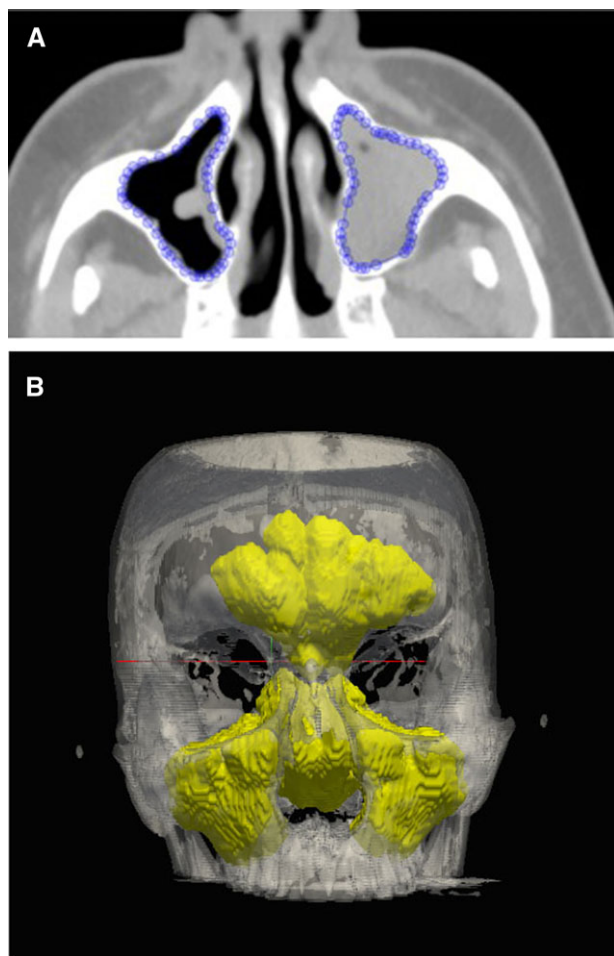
(A) Manually segmented outlines of the anatomic boundaries of the maxillary sinuses on a single CT section image using the ABRAS system (blue). (B) Volumetric analysis is performed by combining the sinus outlines from all CT sections in a scan to yield a 3D rendering (yellow). 3D = three-dimensional; CT = computed tomography.
